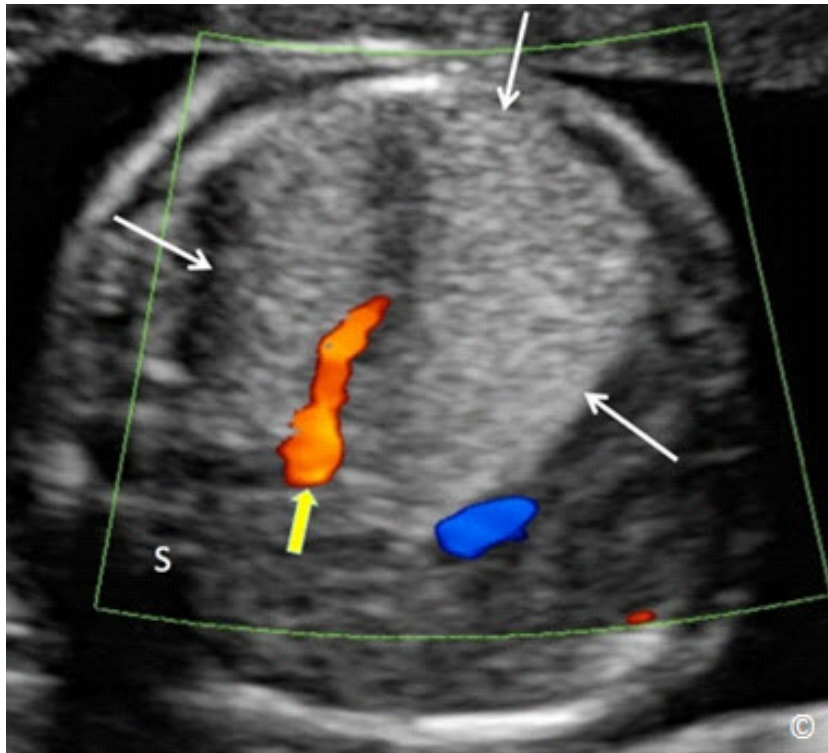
Transverse plane of the chest in 2D and color Doppler modes in a fetus with pulmonary sequestration (white arrows). Note the vascular supply (yellow arrow) that typically arises from the systemic circulation. S = spine
